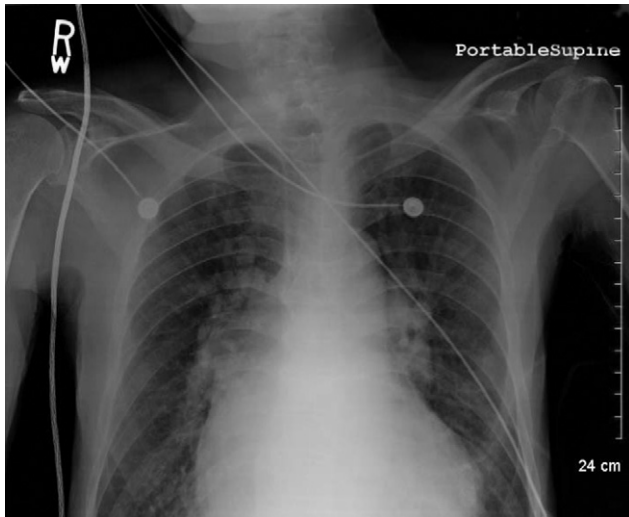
Chest X-ray show bilateral hyperinflated lung, cardiomegaly and perihilar prominence signifying pulmonary artery hypertension and right sided enlargement of the heart.
